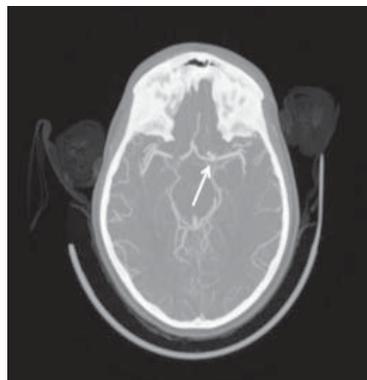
CTA showing lobulated aneurysm arising from left terminal Internal carotid artery.
